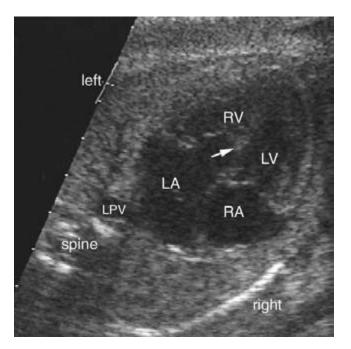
3 Ebstein's malformation of the left-sided tricuspid valve in corrected transposition of the great arteries. Fetal echocardiogram in four-chamber view shows apically displaced attachment (arrow) of the tricuspid valve of the left-sided right ventricle (RV). Note that there is mesocardia and the apex points the midline. LA, left atrium; LPV, left pulmonary vein; LV, left ventricle; RA, right atrium.
